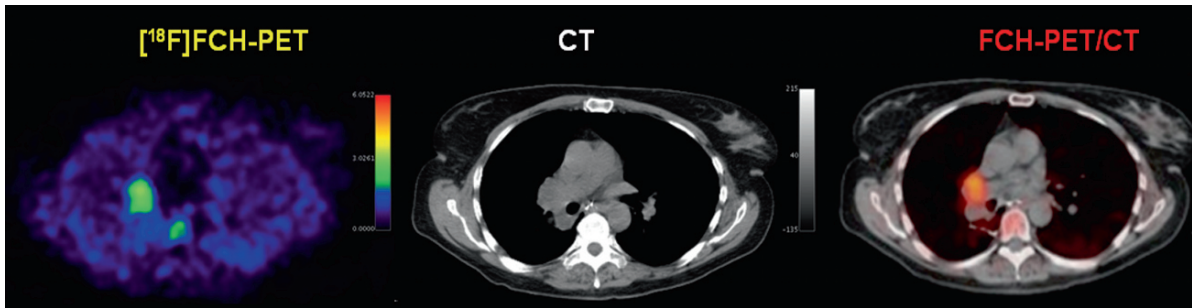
FCH-PET/CT scan in a patient with lung cancer demonstrating the advantage of PET/CT fusion in image interpretation
